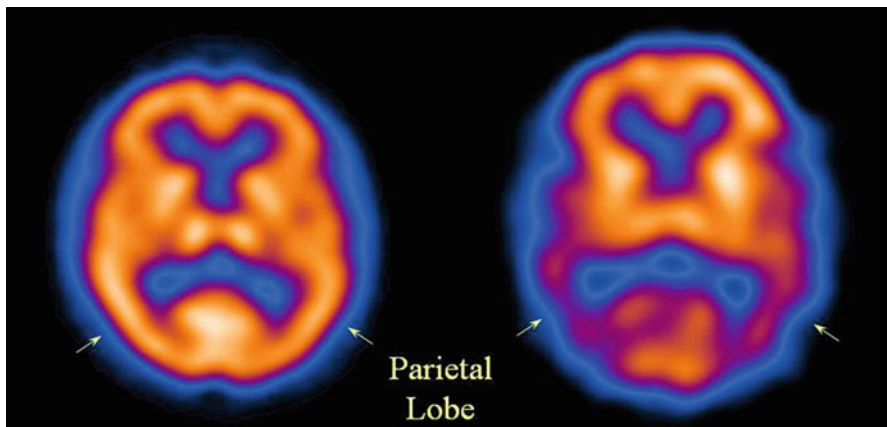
Single photon emission computed tomography (SPECT) image of a healthy control subject (*left*) and patient with AD (*right*). The arrows point to the parietal lobe, showing decreased perfusion in the parietal lobe (normalized to the cerebellar perfusion) in AD, compared to the healthy control subject
